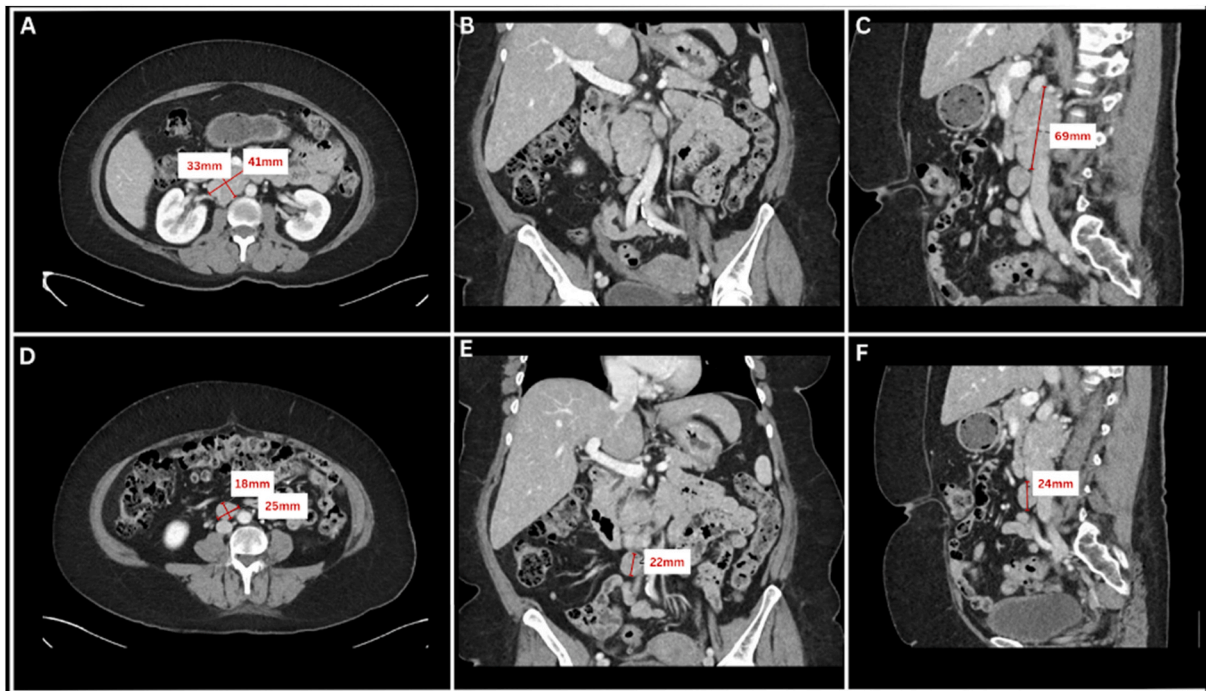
Preoperative CT demonstration of paraganglioma conglomerate - (A) axial, (B) coronal, and (C) sagittal views of infrarenal aortocaval mass [4.1x3.3 × 6.9 cm], with (D) axial, (E) coronal, and (F) sagittal views of inferior nodule at the aortic bifurcation [2.5x1.8 × 2.4 cm].
